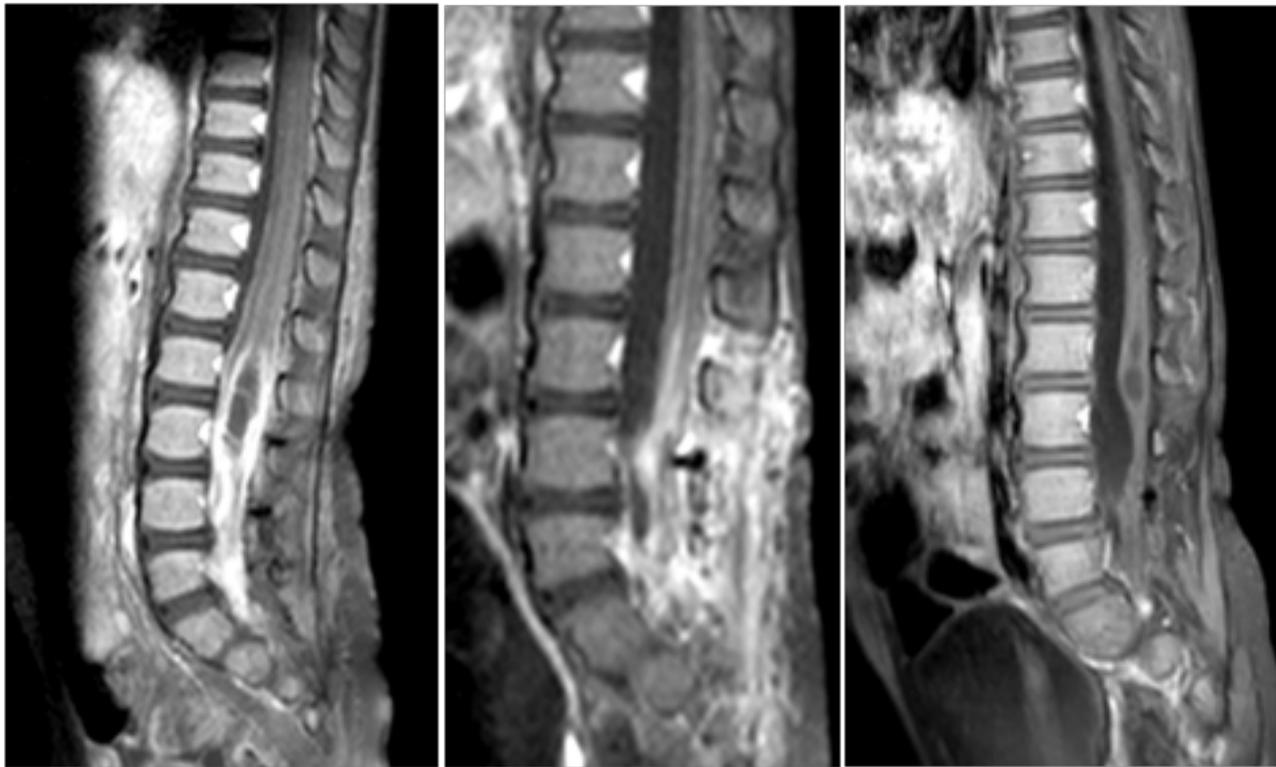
Sagittal T1 MRI with contrast day 1 (A), 19(B), 45(C).
